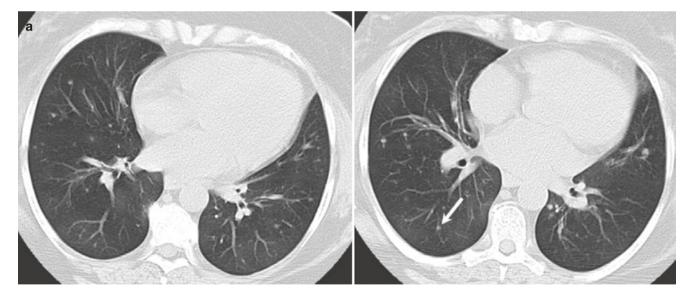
A 53-year-old women with DIPNECH. Axial CT images (a) inspiratory phase shows multiple small nodules (arrows), and bronchial wall thickening, (b) expiratory phase shows air-trapping
